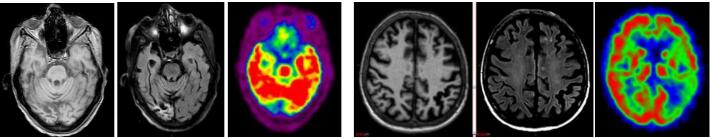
Right mesio-postero-temporal atrophy on MRI imaging (T1 and FLAIR sequences) and corresponding hypometabolic activity on FDG-PET.
